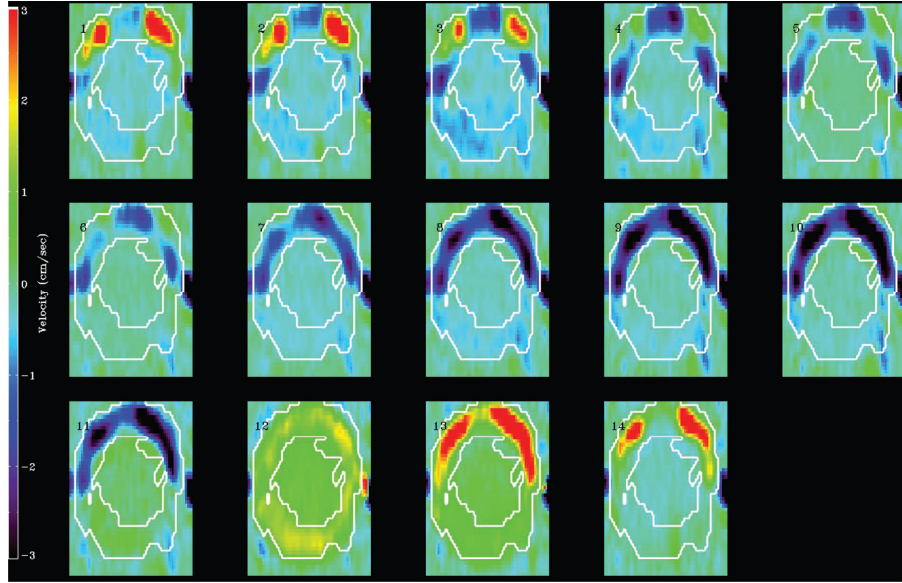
Fourteen successive transverse PC MR images of CSF flow through foramen magnum during cardiac cycle in a symptomatic Chiari I malformation patient. White lines represent the subarachnoid space. 1–5 show cranial CSF flow; 6–11, caudal CSF flow; and 13 and 14, cranial flow again. Color images show pronounced flow inhomogeneity. Regions of the anterolateral SSS have markedly elevated velocities. The posterior part of the SSS, compared to the anterior, is shown to have reduced velocities¹⁰.
